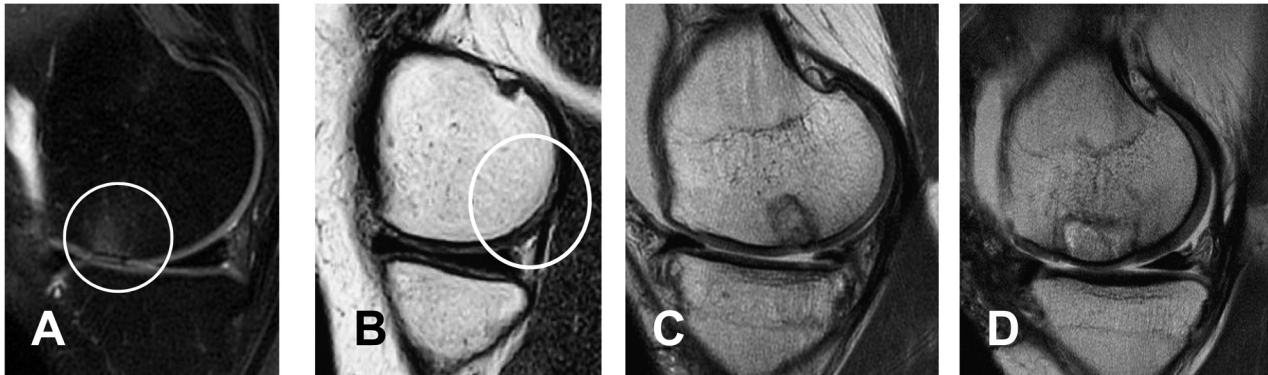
Postoperative magnetic resonance images demonstrating successful articular cartilage repair in athletes who returned to sport after microfracture (A), autologous chondrocyte transplantation (B), osteochondral autograft transfer (C), and osteochondral allograft transplantation (D).
